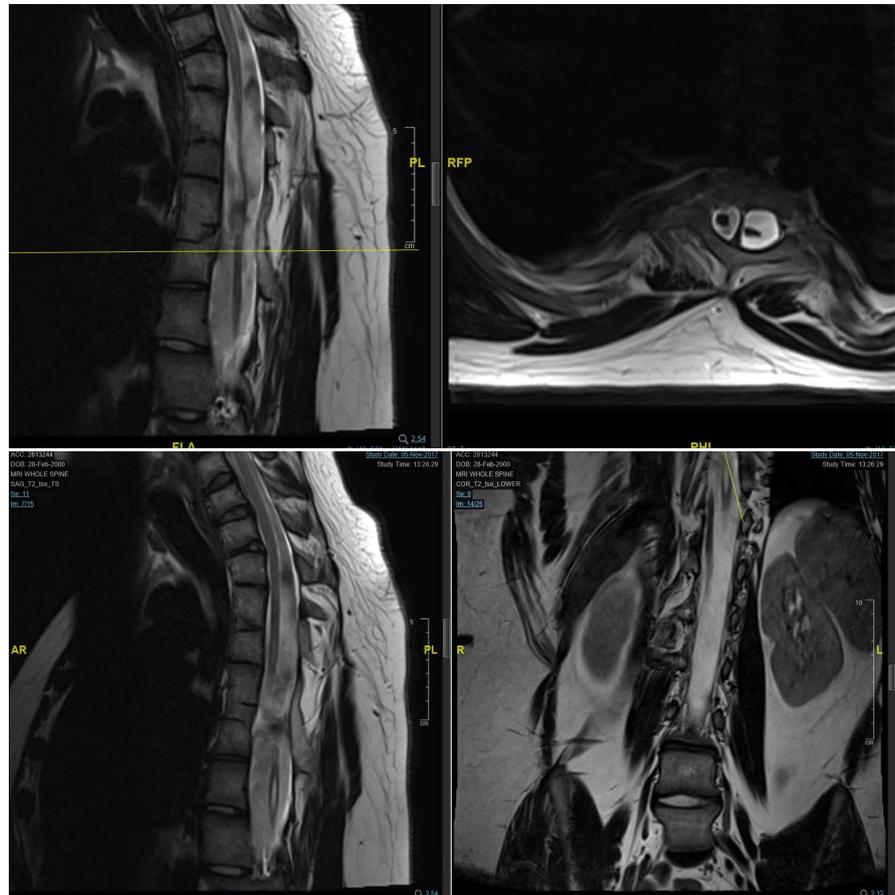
MRI spine shows diastematomyelia and syrinx of the cord.
